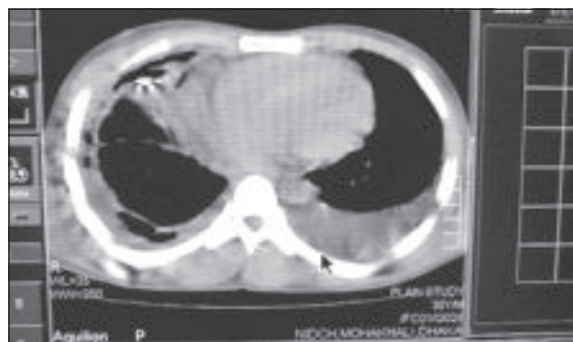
CT Scan of Chest, mediastinal window, shows bilateral encysted pleural effusion
